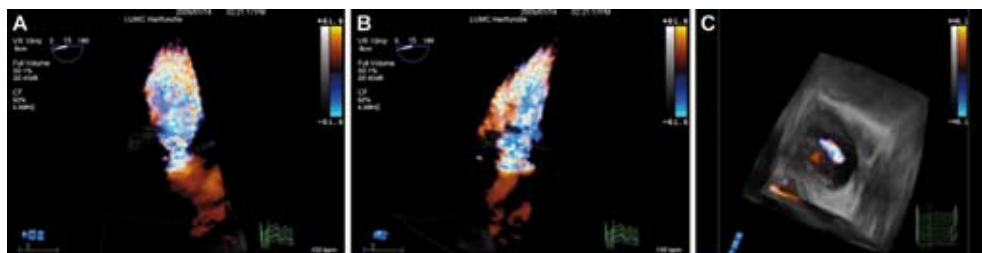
Real-time 3-dimensional echocardiography showing mitral regurgitation color flow Doppler. Two different vena contracta widths in two orthogonal planes (Panel A: 4-chamber view; Panel B: 2-chamber view). En face view (Panel C) show an oval shaped vena contracta.
